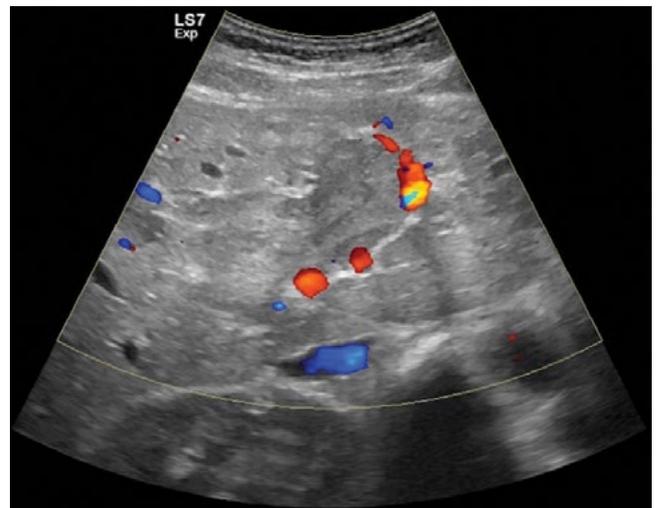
Color Doppler US image reveals the presence of diagnostic arterial flow within the tumor thrombus
